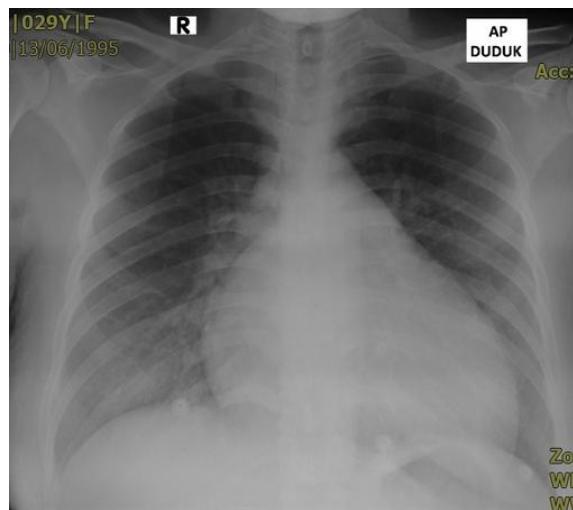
Chest X-Ray showed Cardiomegaly and Pulmonary Congestion.
